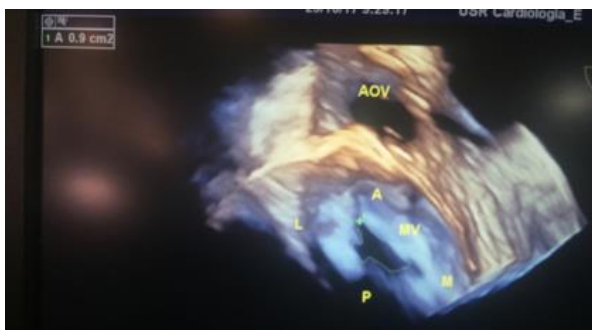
A 3-dimensional transesophageal echodopplercardiogram showing the mitral valve stenosis (planimetry mitral valve area of 0.9cm²).
